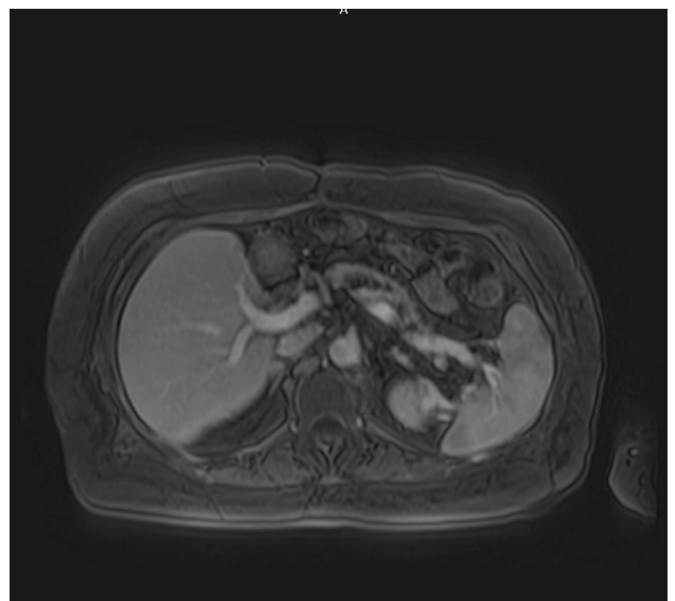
Post-contrast axial MRI taken 8 months post-venous intervention demonstrating patent portal veins.
